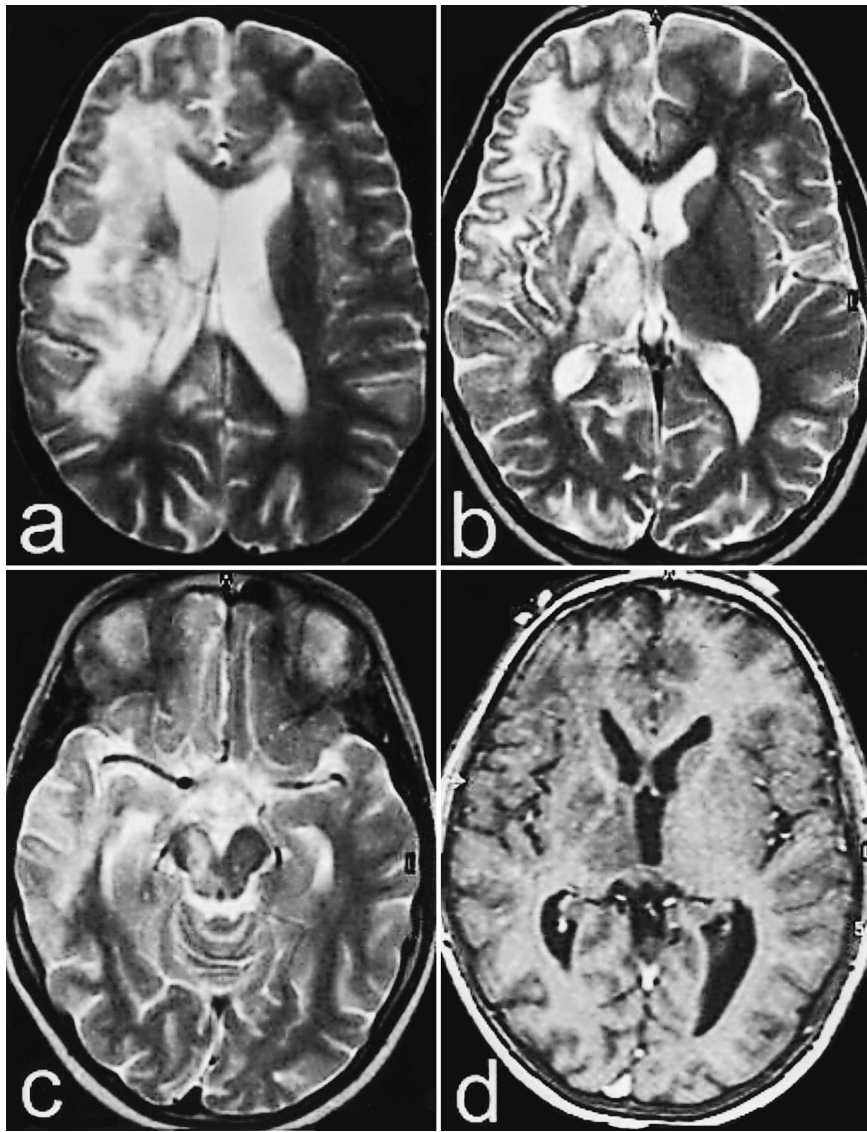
a to d a to c Axial T₂-weighted MRI (TR 2351, TE 90) obtained four weeks after those shown in Fig. 1. Widespread involvement of the right frontal lobe and internal capsule, reaching the right cerebral peduncle, is evident. Mild hyperintensity is present within the left frontal lobe white matter, with initial involvement of the left genu of the corpus callosum. Both lateral ventricles and cerebral sulci are enlarged. d Enhanced axial MRI (T₁-FFE-weighted, TR 30, TE 4.6) shows conspicuous diffuse hypointensity; the enhancement previously present is no longer seen.
